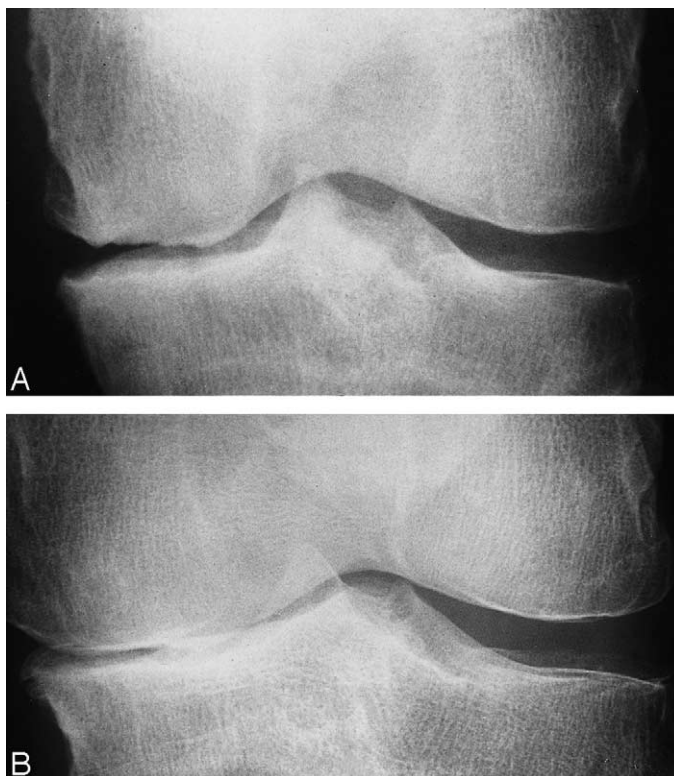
(A) Radiograph of knee with osteoarthritis with medial compartment JSW >2 mm in the standing extended view. As described elsewhere⁵⁰, the joint space visible in the extended knee view does not correspond to articular cartilage thickness at the central region of the tibio-femoral joint, but to a 'gap' produced by the femoral condyle rolling forward onto the ridge at the anterior tibial rim. Importantly, observe in the medial compartment the marked subchondral sclerosis with tongue and groove corrugations on the femoral and tibial articular surfaces. The latter are consistent with the loss of cartilage in the flexed knee position. (B) The same OA knee as in (A) radiographed in the same view, 21 months later, showing marked articular cartilage loss in the medial compartment indicated by the narrowed joint space. With joint space loss, there is an increase in subchondral sclerosis, the articular surfaces appear flattened, and the corrugations visible in (A) are reduced or absent resulting in greater articular congruence, changes that are consistent with weak subchondral bone reported at OA joints⁴⁹.
